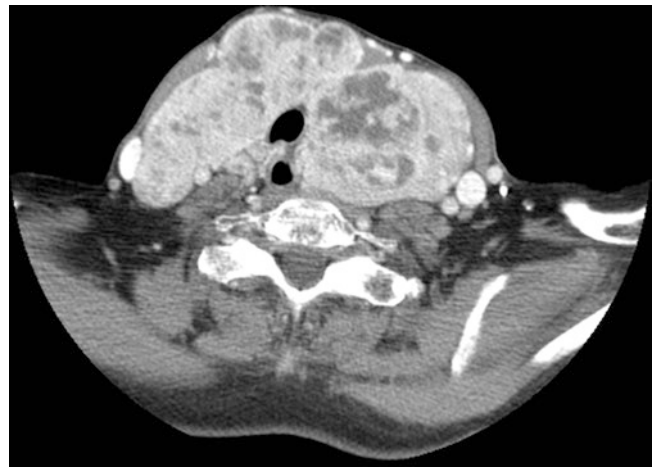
Axial computed tomography (CT) of the neck demonstrating a large goiter with narrowing of the airway but no obstruction
